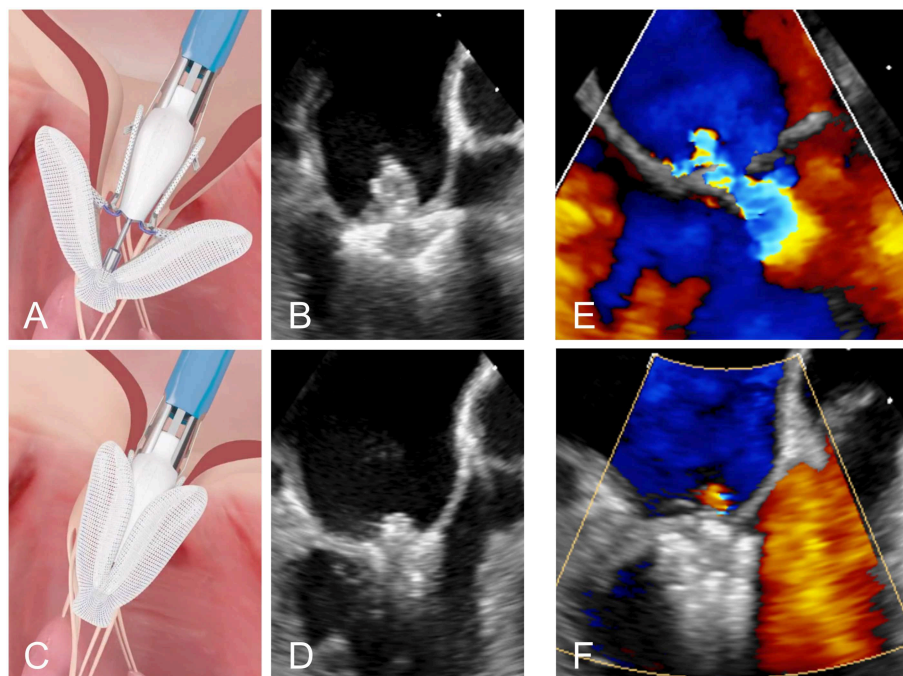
(A,B) Positioning of the PASCAL device in the mitral valve. (C,D) Grasping of the two leaflets. (E,F) Transesophageal Doppler image of a case of severe MR before and after leaflet repair with the PASCAL device, respectively.
